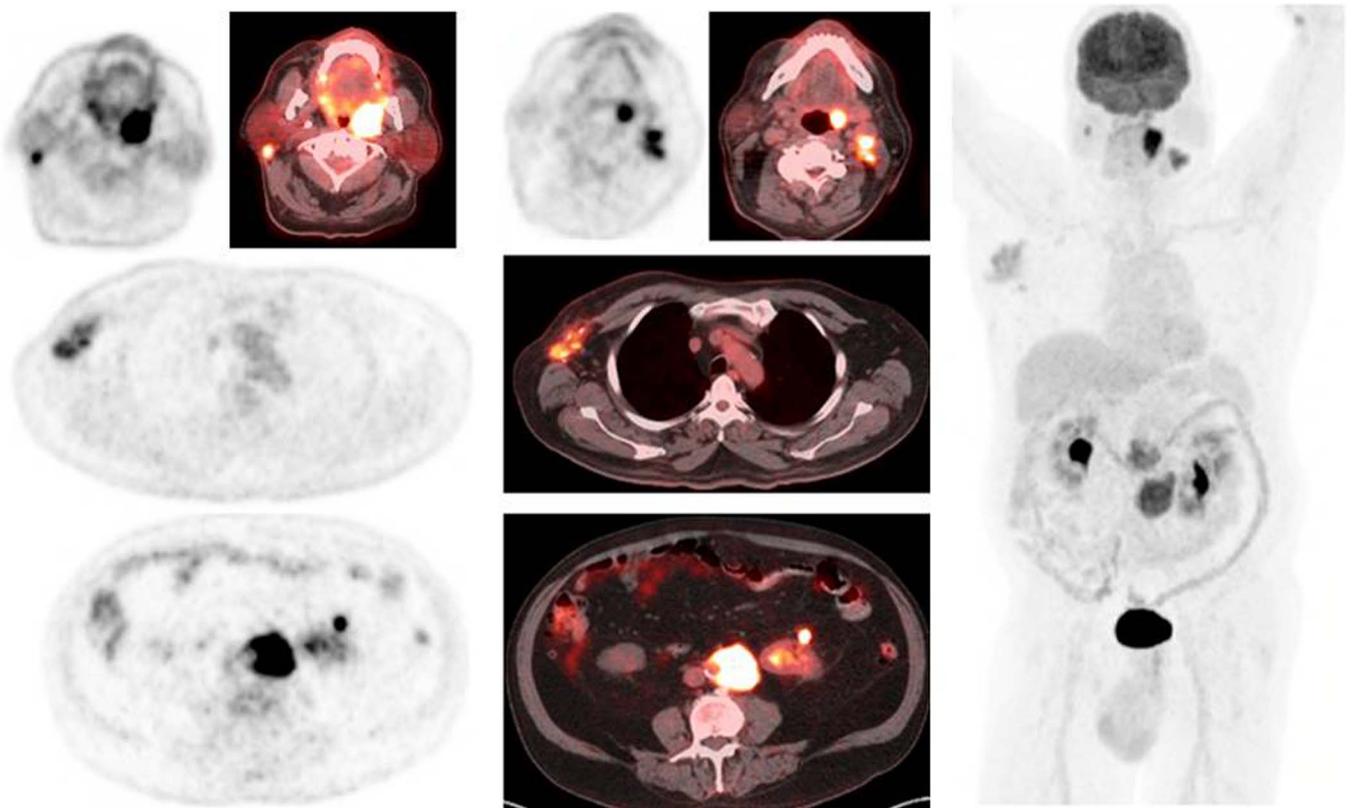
Staging–synchronous tumors. A 68-year-old man presented with a right axillary mass and biopsy results showed grade II follicular lymphoma. He underwent an ^{18}F -FDG PET/CT for staging. Images showed intensely hypermetabolic soft tissue mass in left palatine tonsil, hypermetabolic left level II cervical node, right intraparotid node, and confluent nodal mass surrounding abdominal aorta. Further workup of the left cervical level II LN revealed metastatic squamous cell carcinoma, p16 positive.
